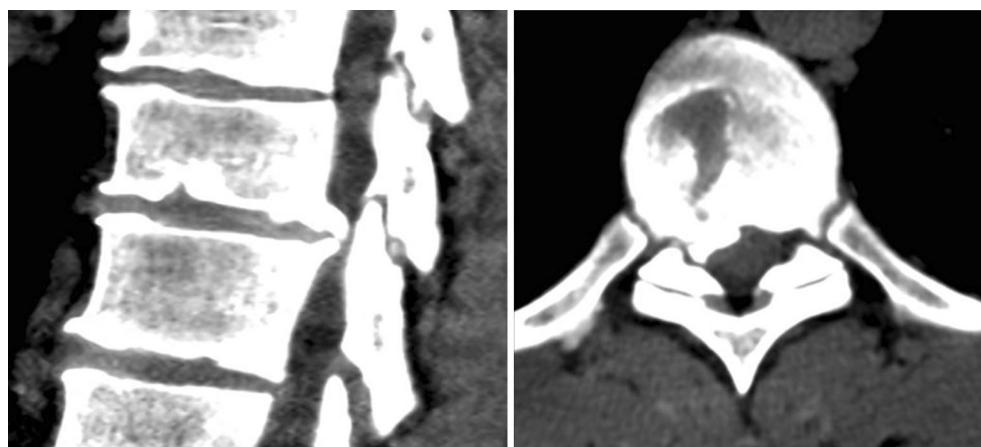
Case 1 CT shows the herniation as densely calcified
